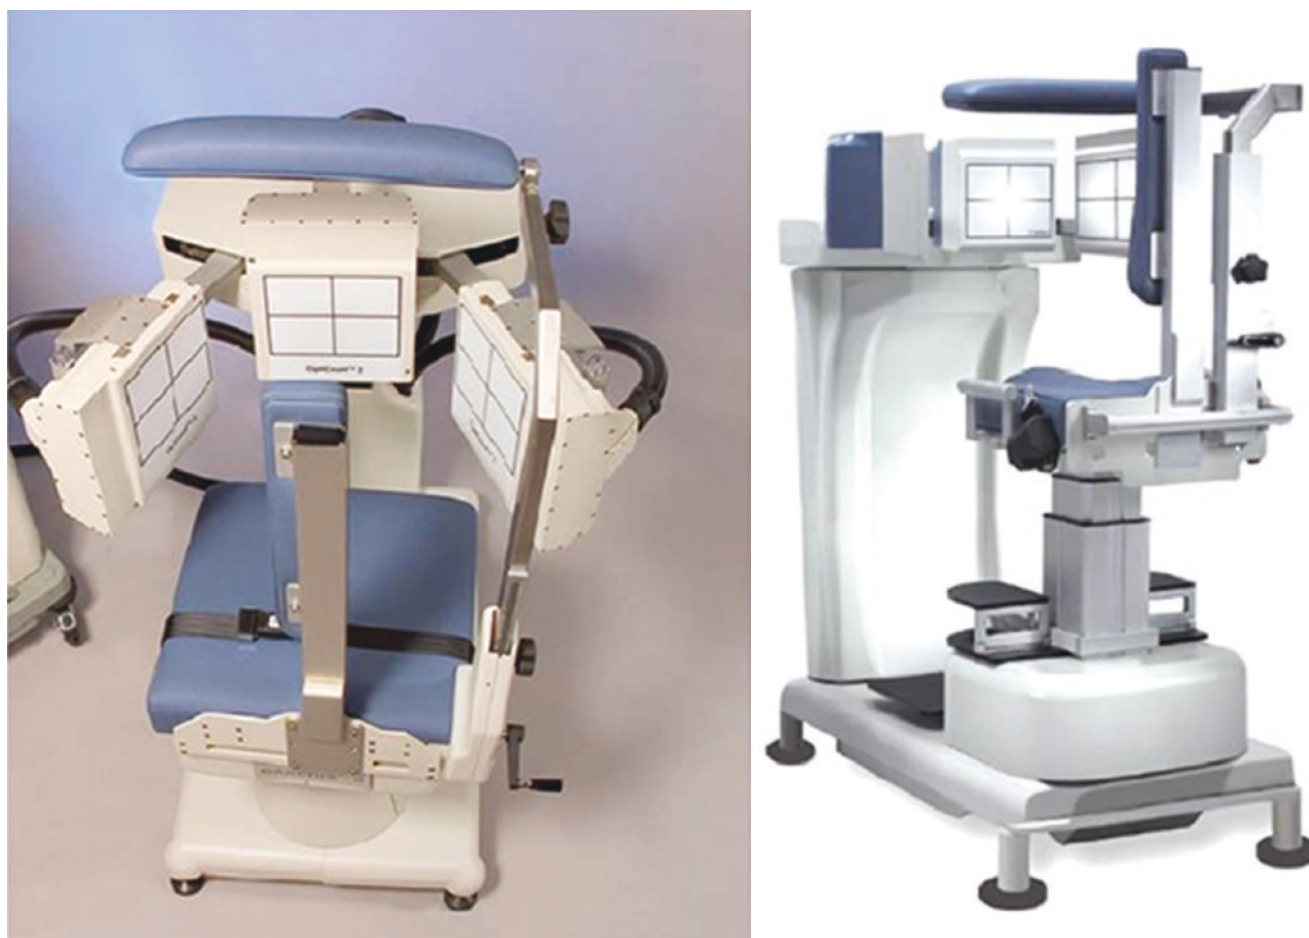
The Digirad Cardius 3 XPO™ system. The patient is seated upright, and the chair rotates to achieve the required angular sampling (*reproduced from: Slomka PJ, Berman DS, Germano G. New cardiac cameras: single-photon emission CT and PET. Semin Nucl Med. 2014;44:232–51*)
